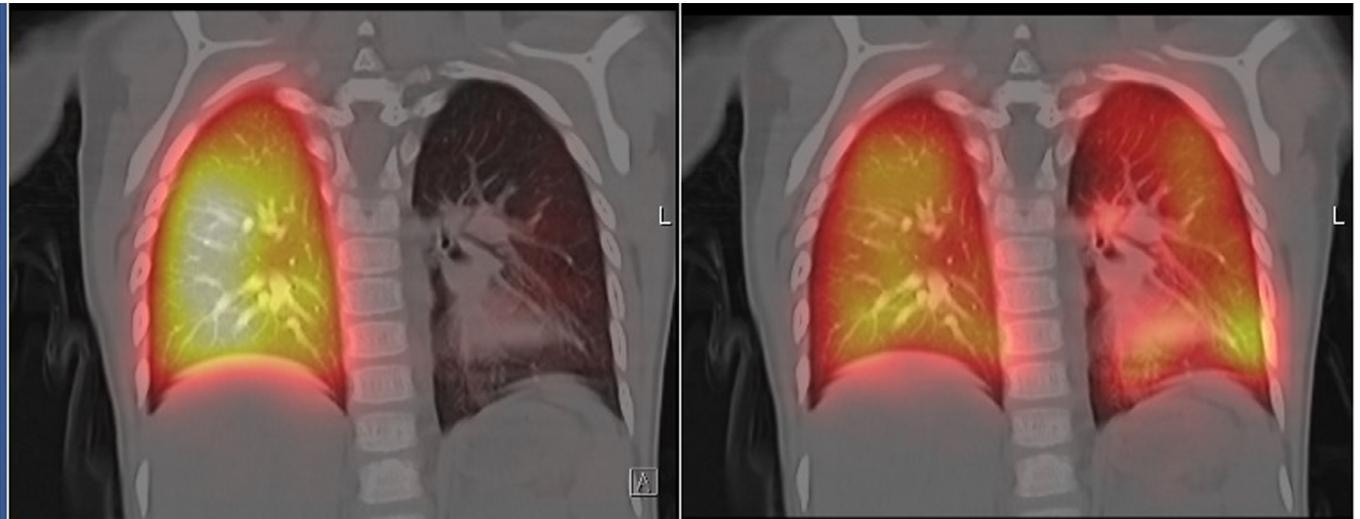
Upper panel, coronal section of the fused SPEC/CT of the pulmonary perfusion (left) and ventilation (right) distributions in a 5-year-old patient with Fallot anomaly. The bottom panel shows the corresponding total lung volume functional V/Q ratio distribution.
